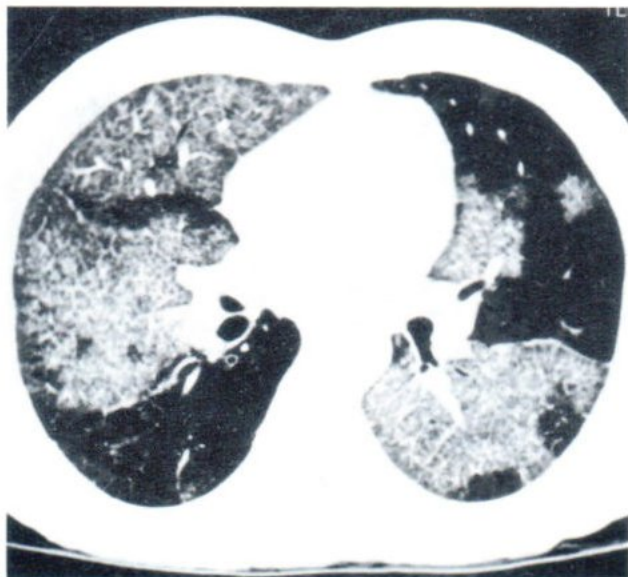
PAP. HRCT chest of a 52-year-old man, who presented with dyspnea for 1 mo., demonstrated discrete geographic areas of crazy-paving pattern in both lung fields. Pathologic findings supported the diagnosis of PAP.
